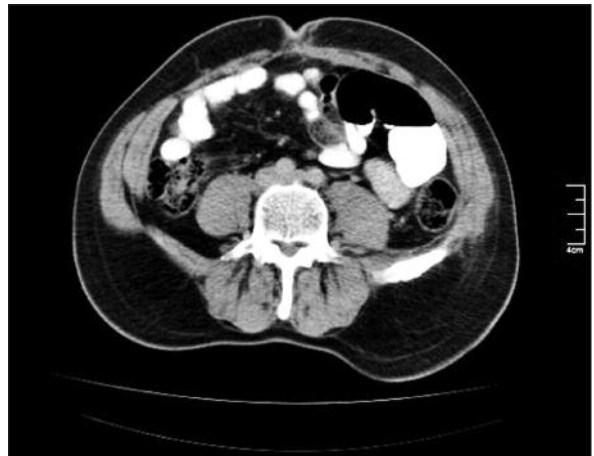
A computed tomography scene of the patient at six months after repair.
